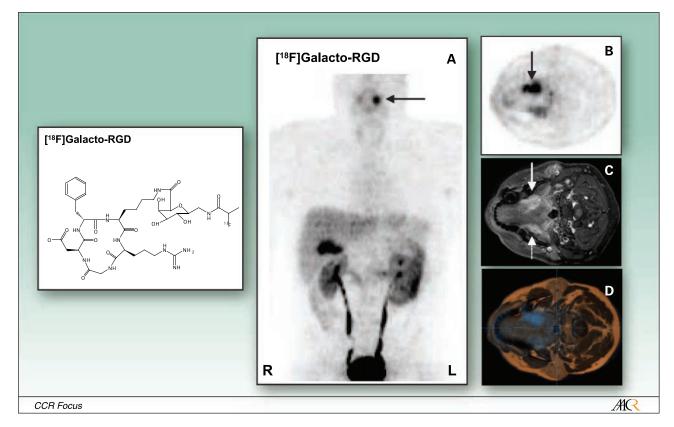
[18F] Galacto-RGD. Arrows, [18F] Galacto-RGD-PET and magnetic resonance tomography of a patient with a squamous cell carcinoma. Physiologic uptake in the spleen and predominantly renal excretion of the tracer (kidney, ureter, and bladder). *A,* maximum intensity projection of [18F] Galacto-RGD-PET. *B,* transaxial section of [18F] Galacto-RGD-PET. *C,* T1 section with contrast enhancement of the corresponding magnetic resonance imaging scan. *D,* fused transaxial sections of [18F] Galacto-RGD-PET and T1 section with contrast enhancement.
